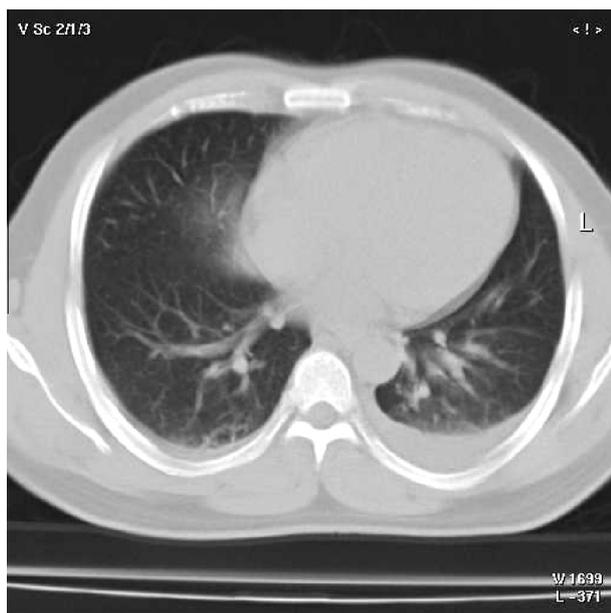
HRCT of lung window of lower lung zone in an early SLE patient revealed: left pleural effusion, bilateral basal fine sub-pulmonary thin septation with minimal small cystic changes.
